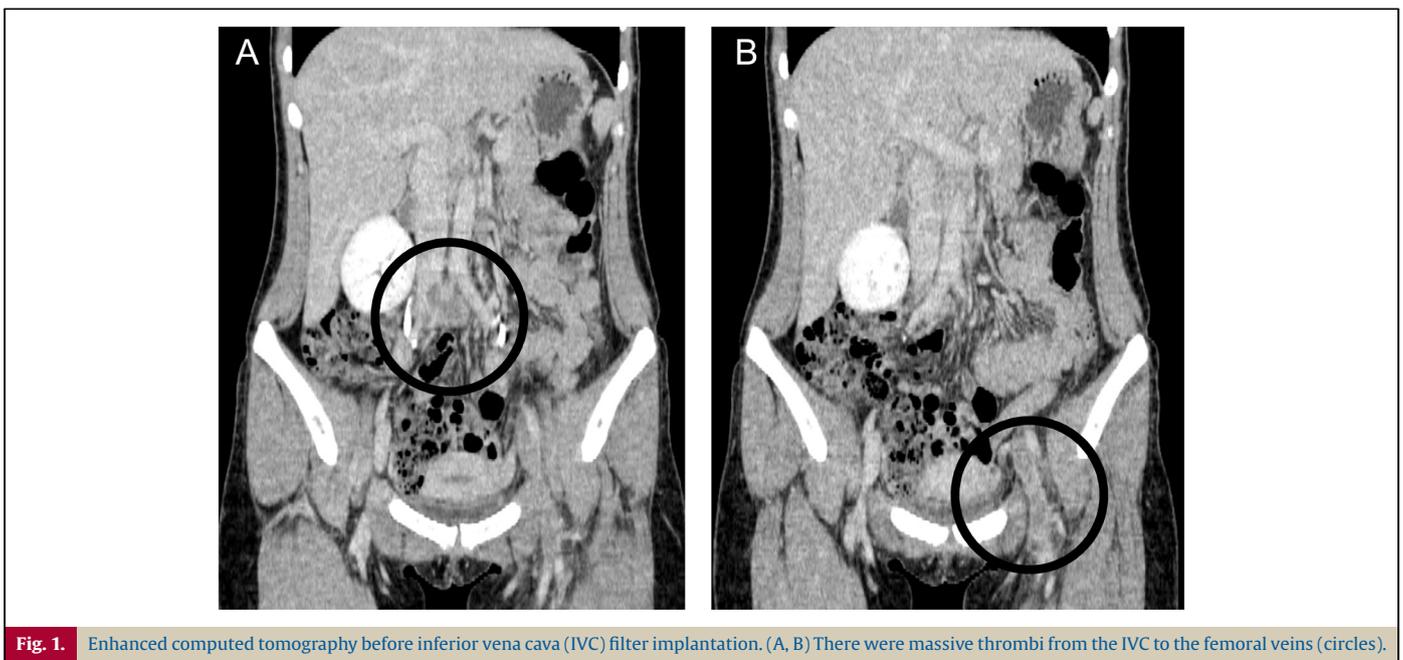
Enhanced computed tomography before inferior vena cava (IVC) filter implantation. (A, B) There were massive thrombi from the IVC to the femoral veins (circles).
